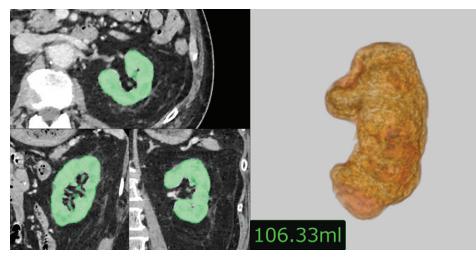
Images show axial, sagittal, and frontal rendering of CT data used to determine kidney volume (left). Volume of green highlighted area was measured as kidney volume. Volume rendering of kidney (right) shows estimated volume in left corner.
